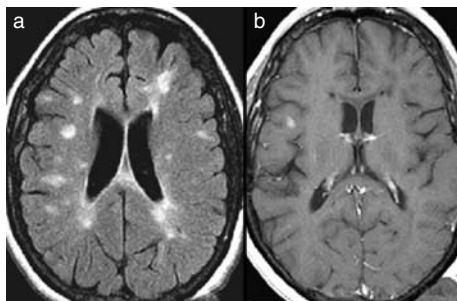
This axial T1-weighted MR-scan shows several brightly hyperintense periventricular and white matter plaques (a). One subcortical plaque is seen after administration of paramagnetic contrast (b).
